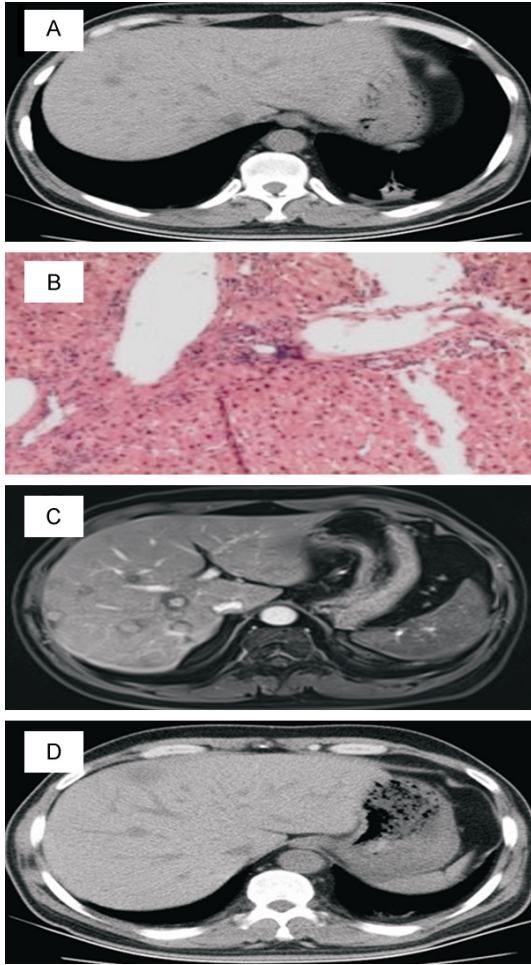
Presentation of Case 5. A. CT scan showed multiple nodular lesions in the liver. B. Ultrasound-guided fine needle aspiration biopsy showed no evident inflammation and fibrosis. C. Contrast-enhanced CT showed that after the discontinuation of daptomycin for twenty days, hypo-density nodular lesions in the liver got bigger and more than before, with the diameter of about 18 mm and well-circumscribed. D. About two months after the discontinuation of daptomycin, only two nodular lesions were left in the liver.
